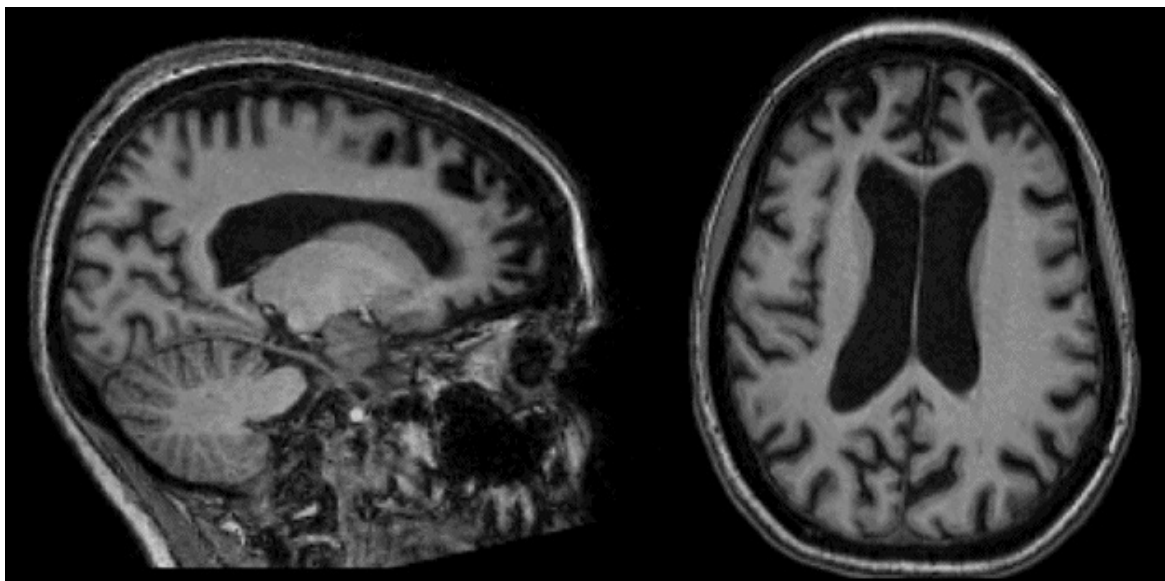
This 49-year-old woman developed gradually progressive difficulty performing the duties of her job and her routine home activities with her family (insidious functional impairment). She had apathy and disinhibition, was impulsive, and no longer seemed to express concern as she had previously done for her daughter's problems (lack of empathy). There was no obvious memory loss or spatial disorientation. On examination, she had severe impairments in working memory and executive function (with perseveration and difficulties with phonemic verbal fluency). Brain MRI showed prominent prefrontal atrophy on sagittal (left) and axial (right) T1-weighted images. Diagnosis was probable bvFTD.
